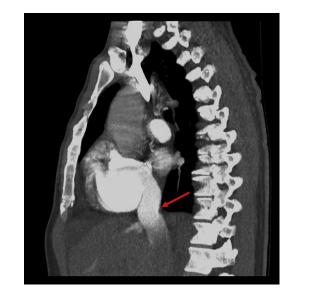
Contrast-enhanced CT of the chest, sagittal view, showing reflux of iodinated contrast into the inferior vena cava (*red arrow*).
